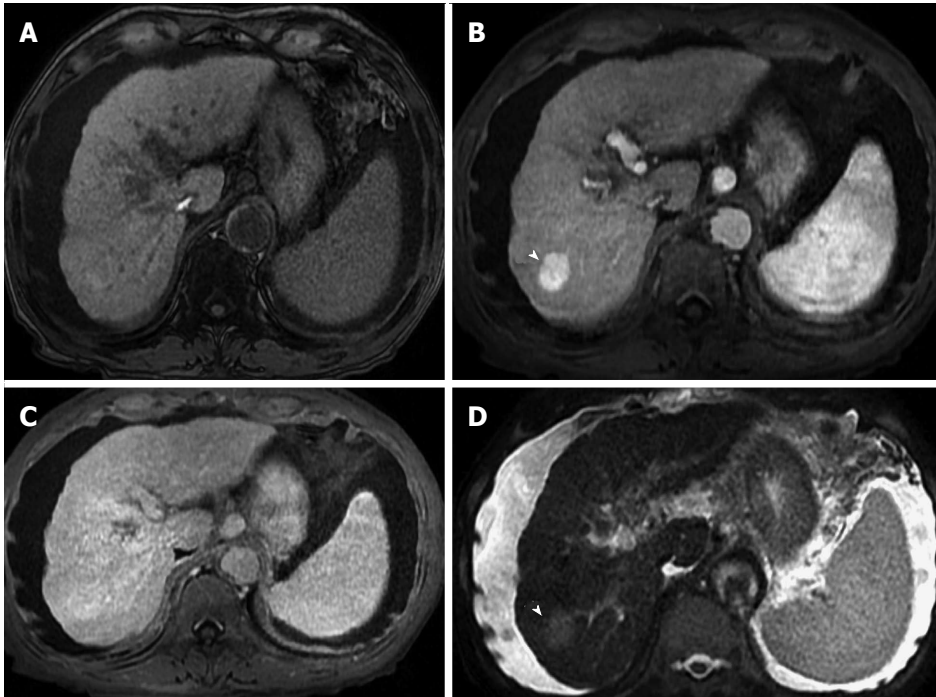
Large, non-washing-out hepatocellular carcinoma. A: Pre- and post-contrast fat-suppressed 3D-GRE T1-weighted images during the (B) late hepatic arterial and (C) delayed phases; D: Fat-suppressed SSFSE T2-weighted image. There is a sizable right hepatic lobe nodule, which demonstrates iso T1 signal intensity on pre-contrast images (A); increased arterial enhancement (arrowhead, B); becomes iso to slightly hyperintense compared to background liver, without definite washout, on the delayed images (C); and demonstrates mildly increased T2 signal intensity in keeping with HCC. Note that T2 signal alteration increased the accuracy of diagnosing HCC in this patient, despite the lack of delayed washout (also see Figure 12). HCC: Hepatocellular carcinoma; GRE: Gradient recalled echo; SSFSE: Single-shot fast spin-echo.
